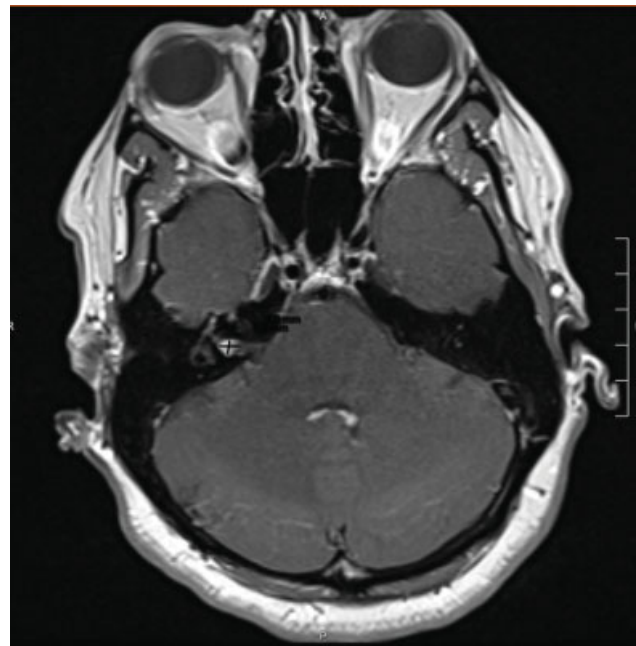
Axial MRI T1 postcontrast sequence at the level of the IAC demonstrating a 6 × 4 mm enhancing intracanalicular lesion in the right internal auditory canal.
